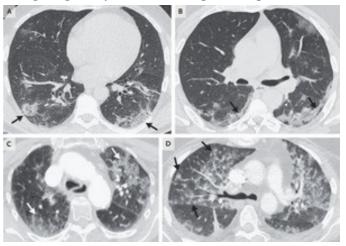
Pattern of CT findings in Covid-19 patients.⁶
